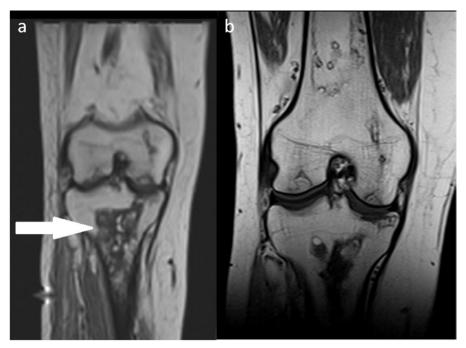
(a) November 30, 2020: Follow-up MRI after 5 months from the right knee (Coronal T1w) showed multi-focal avascular and subchondral necrosis in the epiphysis of femorotibial joint accompanied with 1.5 mm depression at medial tibial plateau in the site of subchondral bony infarct. (Arrows indicate bone necrosis). (b) August 19, 2020: The previous right tibial osteomyelitis was partially resolved.
